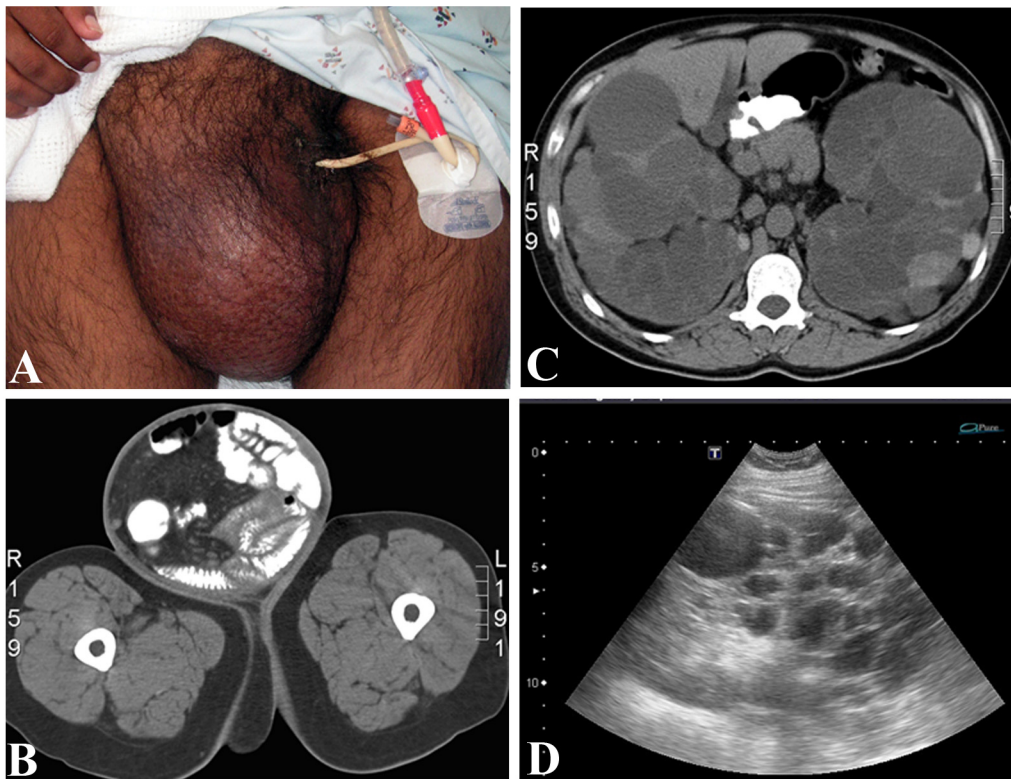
A, Gross appearance of inguinal hernia. B, computed tomography showing large inguinal hernia containing small bowel and cecum with intraluminal contrast. C, appearance of bilaterally-enlarged kidneys with innumerable cysts. D, emergency department ultrasound image of the right upper quadrant showing multiple cystic structures.
